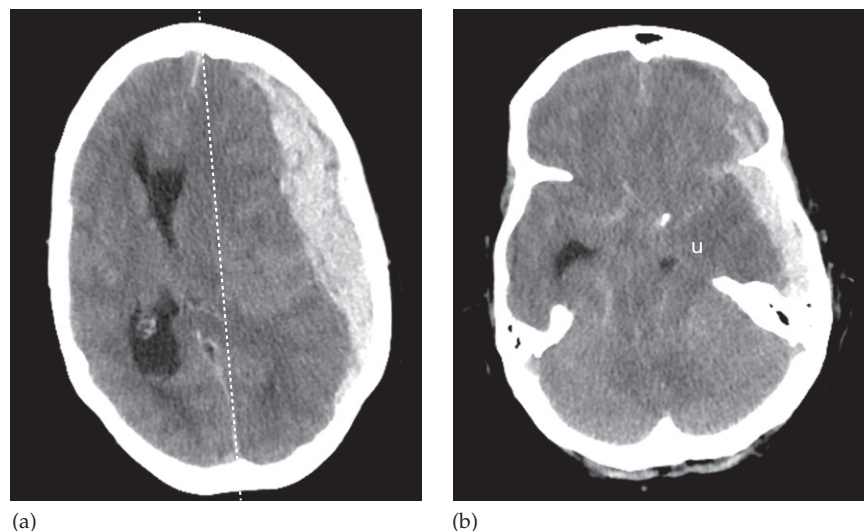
Brain herniation. Unenhanced CT scans showing subfalcine and downward transtentorial herniation due to an acute subdural haematoma. (a) In subfalcine herniation there is a shift of brain and ventricles across the midline (dashed line). (b) In downward transtentorial herniation there is obliteration of the normal CSF-containing basal cisterns and herniation of the medial temporal lobe over the tentorium cerebellum. u, uncus.
